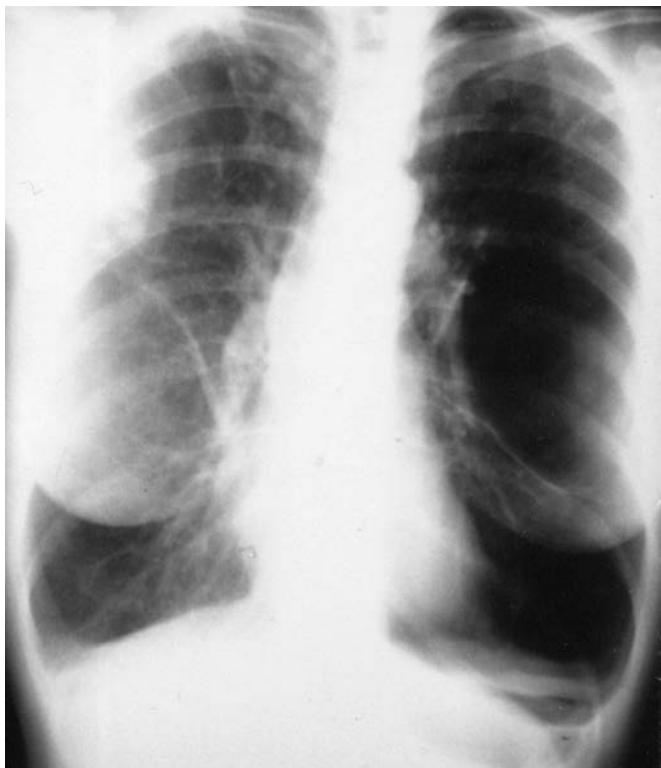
Chest radiograph of a patient with severe emphysema and multiple bullae including giant bullae of the left upper and lower lobes. This patient also has a carcinoma of the right upper lobe.
